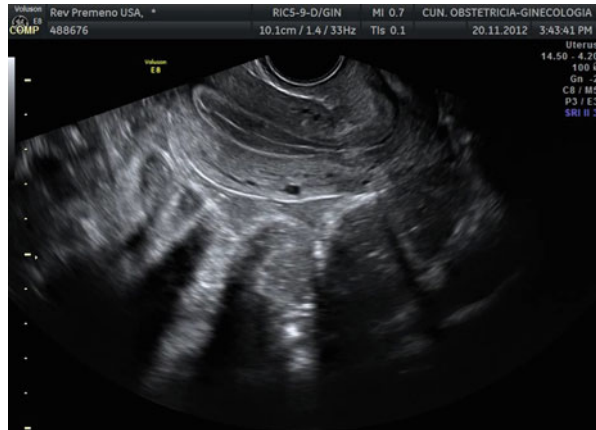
Transvaginal ultrasound during secretory phase showing a homogeneous echogenic endometrium
